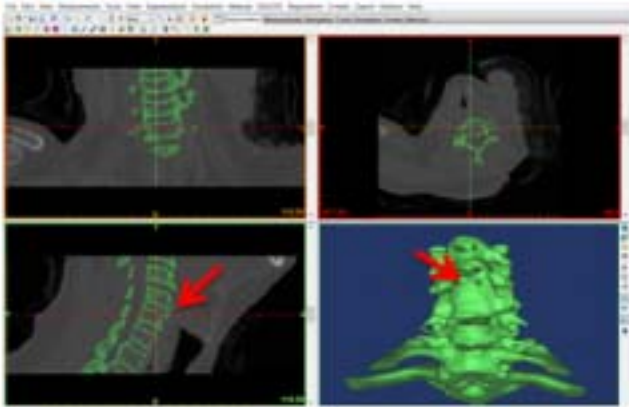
CT data scan of the patients' anatomical data
